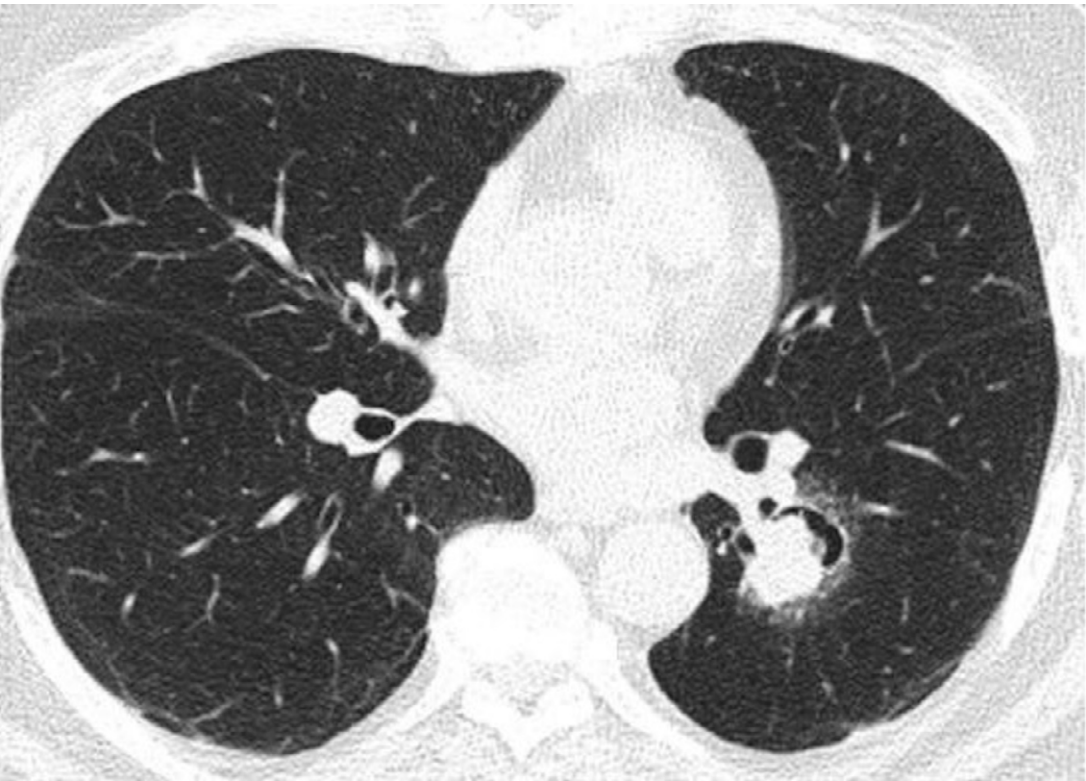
An axial CT scan with lung window settings showing the air crescent sign in a male patient with lung cancer in the left lower lobe.
